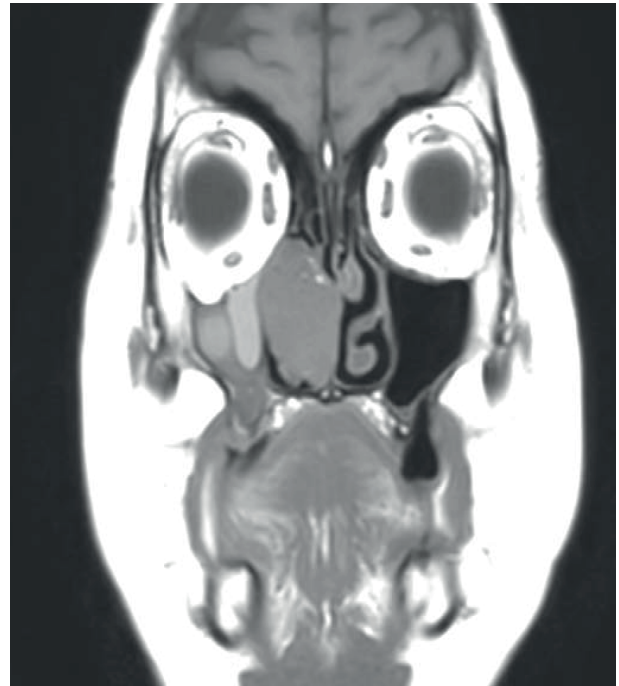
Contrast-enhanced maxillofacial MRI displaying signal changes suggestive of solid tissue within a significant portion of the left nasal cavity. The origin is likely the middle turbinate, as observed to be isointense in T1 and hyperintense in T2 accompanied by irregular pathological contrast impregnation.
